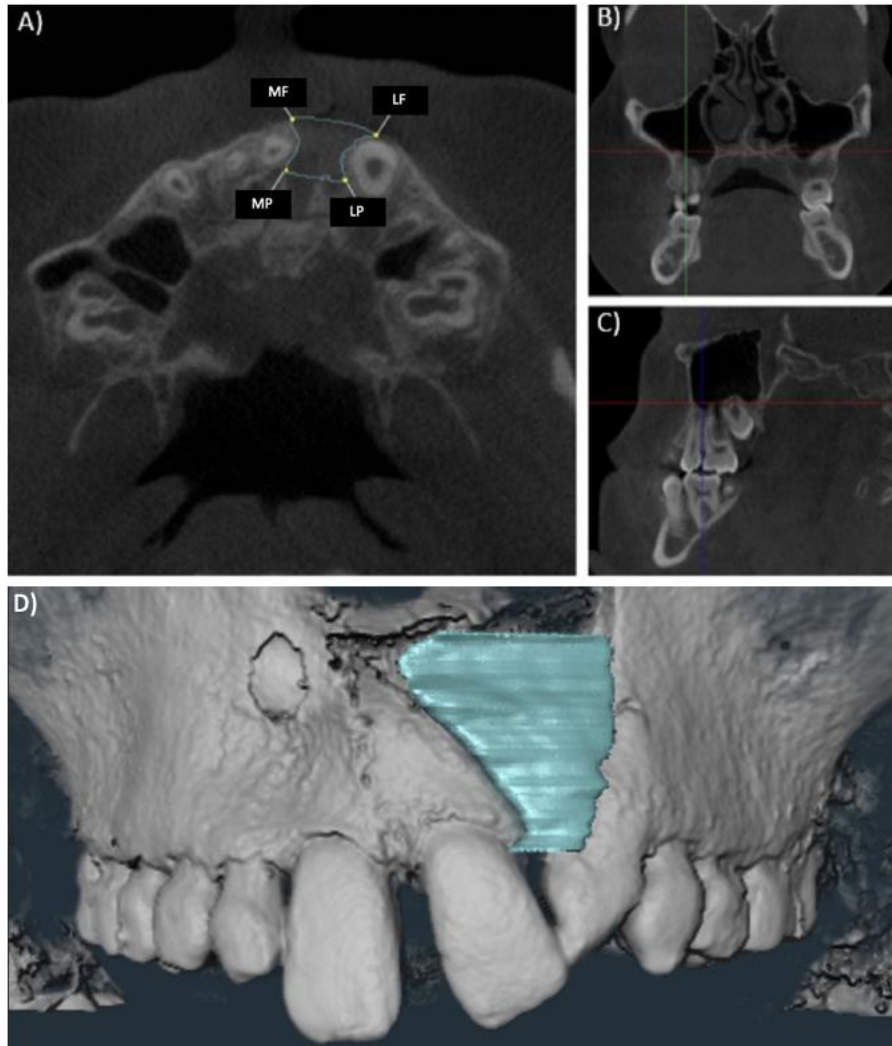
Display of landmarks used to define the alveolar cleft A) Axial CBCT slice showing identification of the most medial-facial border (MF) and most lateral-facial border (LF) of the alveolar cleft. The medial-palatal landmark was placed 8 mm palatal to medial-facial and the lateral-palatal landmark was placed 8 mm palatal of lateral-facial. B) Coronal and C) Sagittal slices at the mesial of the maxillary 1st molar of the non-cleft side showing identification of the most superior portion of the alveolar cleft (red lines) at the lower border of the nasal floor on the non-cleft side. D) Facial view of 3D cleft mask, extending superiorly from the lower border of the nasal floor and inferiorly to the CEJ of the cleft side central incisor.
